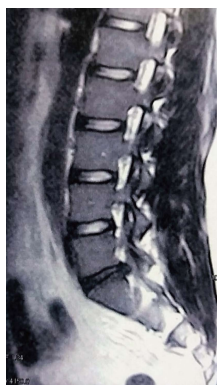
T2 weighted sagittal magnetic resonance imaging demonstrating a disc herniation located at the L5/S1 level.
